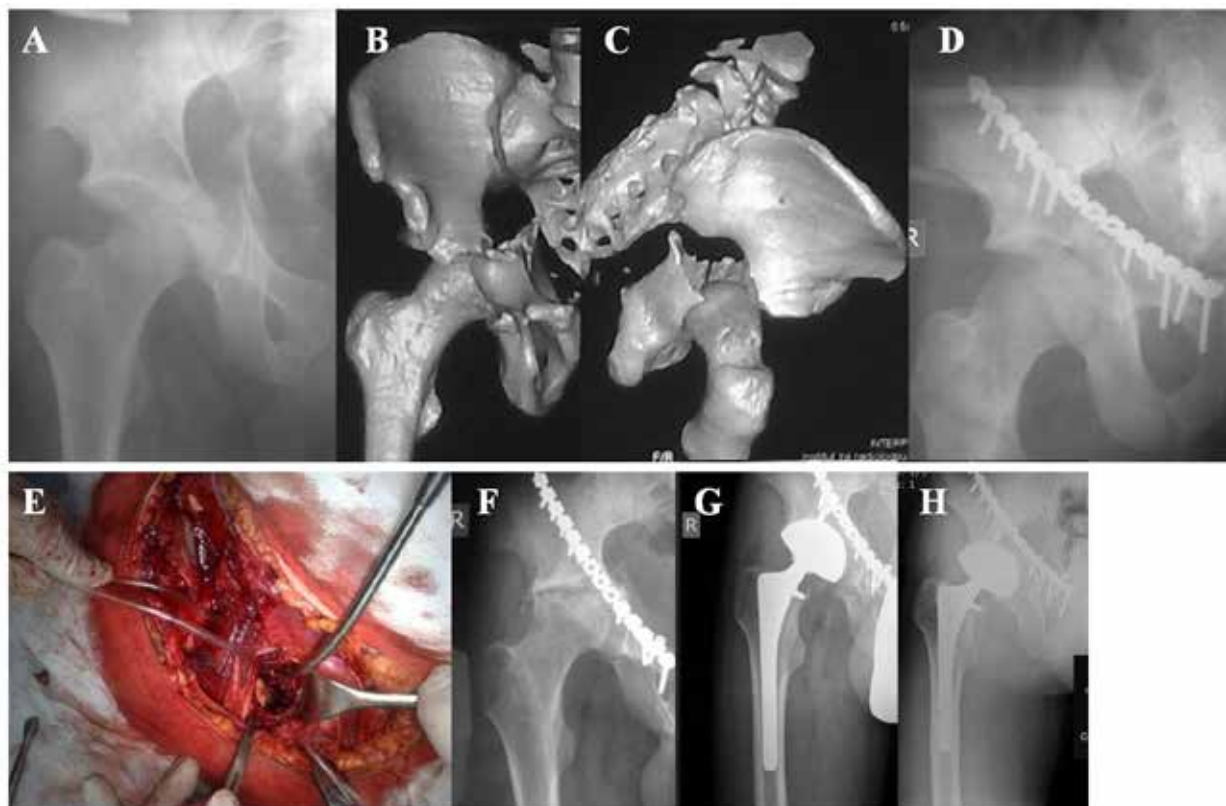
(A-H). THA after previous acetabular fracture and osteosynthesis. A- Transverse acetabular fracture- X-ray; B,C- 3D- CT; D- X- ray after acetabular osteosynthesis; E- Intraoperative view- Ilio-inguinal surgical approach; F- AVN of the femoral head and secondary OA, 4 years after acetabular surgery- X-ray; G- Uncemented THA , 4 years after the injury- X-ray; H- X-ray, 7 years after surgery.
